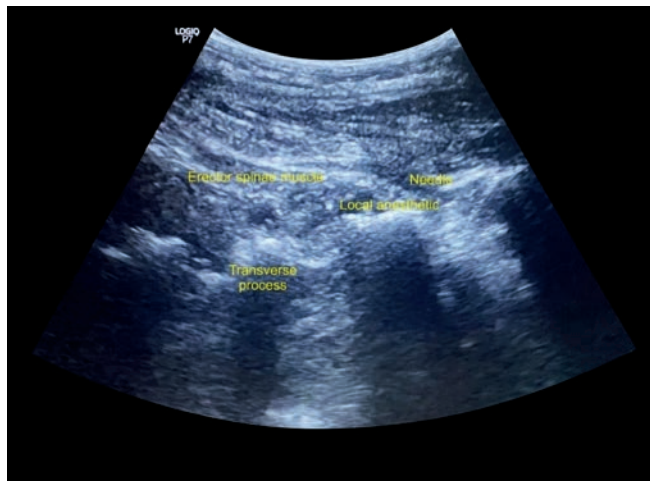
Ultrasound image of erector spinae plane block (ESP block)
